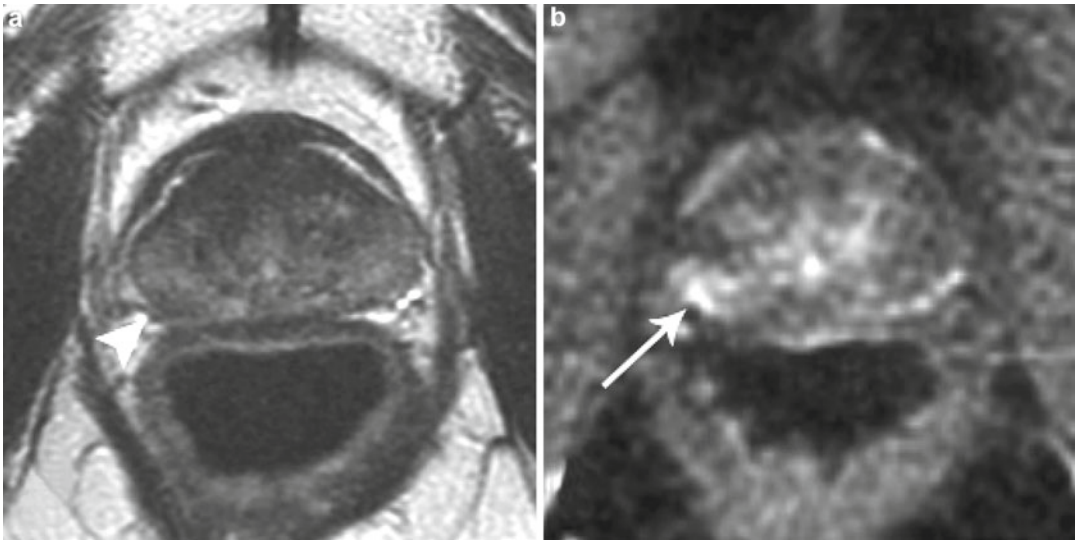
Multiparametric MR images (a – T2-weighted image; b – dynamic contrast-enhanced image) obtained in a 69-year-old patient with history of radiation therapy for prostate cancer 10 years before. The nadir of the PSA level after radiation therapy was 0.8 ng/ml. The PSA level had slowly increased to 3.21 ng/ml at the time of MRI.
